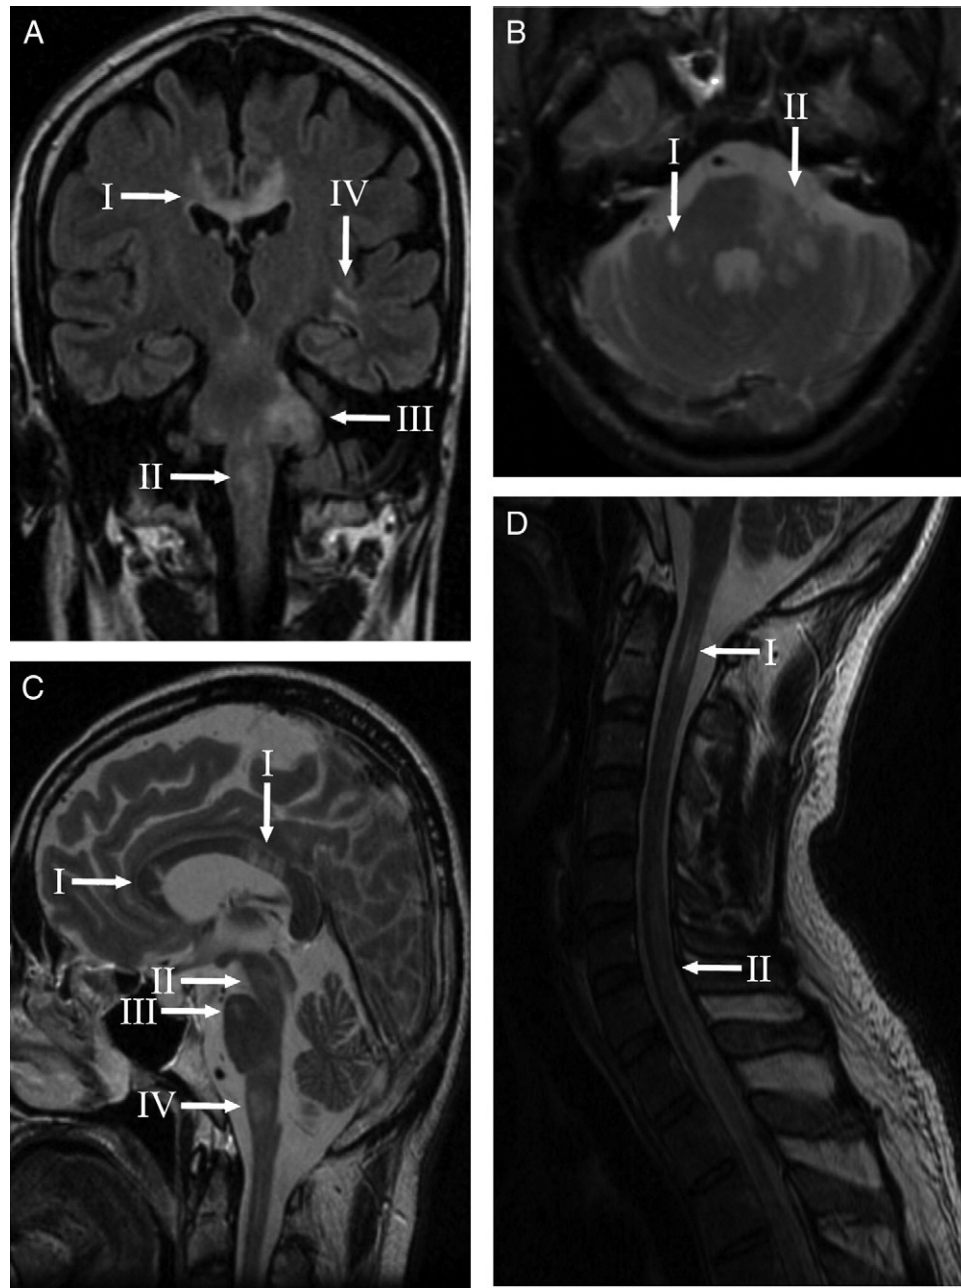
Structural MRI obtained from the patient. White arrowheads indicate areas of abnormality. The coronal flair (A) demonstrates T2 prolongation in the corpus callosum (I), medulla (II), left pons (III) and left temporal lobe (IV). The axial T2 image (B) demonstrates T2 prolongation in the right brachium pontis (I) and left pons/brachium pontis extending into the cerebellar white matter (II). The sagittal T2 image (C) demonstrates T2 prolongation in the corpus callosum (I), midbrain (II), pons (III) and medulla (IV). The sagittal spinal T2 image (D) demonstrates T2 prolongation at the C2 level (I) as well as a longitudinal lesion from the C4/5 level extending into thoracic cord to at least T4 with associated volume loss (II).
